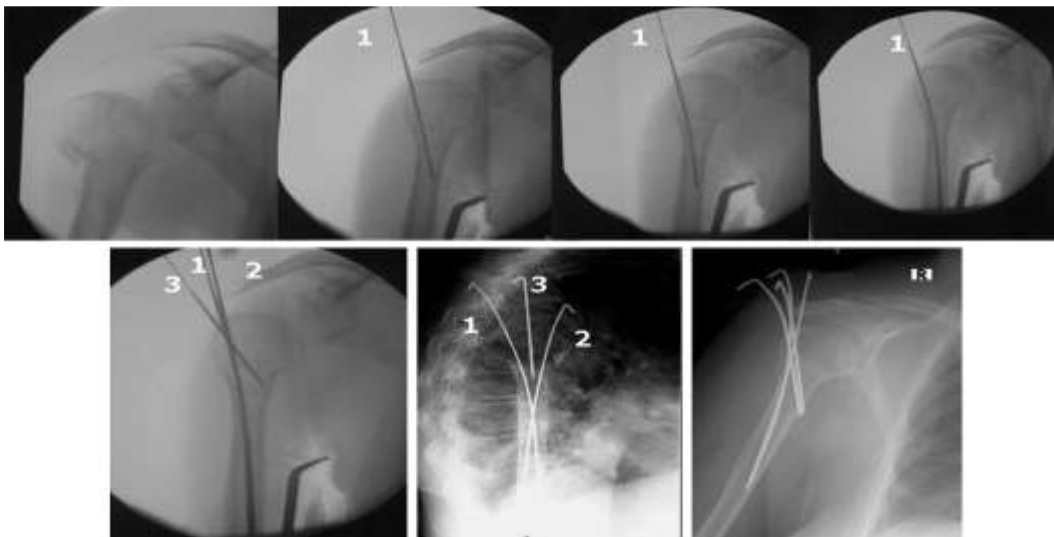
Intraoperative C-arm images of a patient that show the reduction of the fragments by using reduction and antirotating pins and an anteroposterior/lateral x-ray of the same patient at 4 weeks after the operation. (1) Reduction pin; (2) antirotating pin; (3) stabilizing pin (19)
